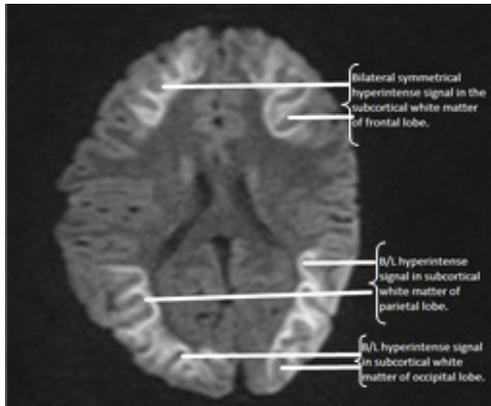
MRI of brain – before treatment
